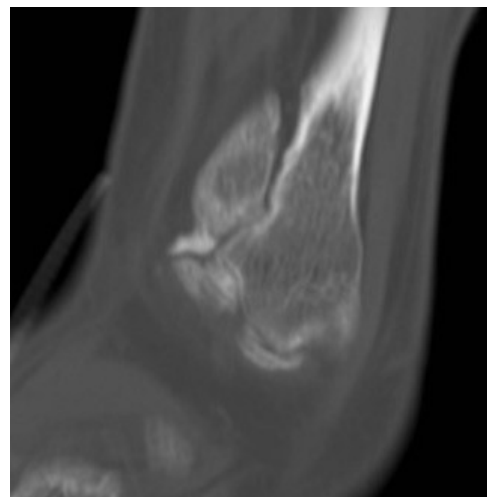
Fibrous fibular-talar coalition CT sagittal MPR.
